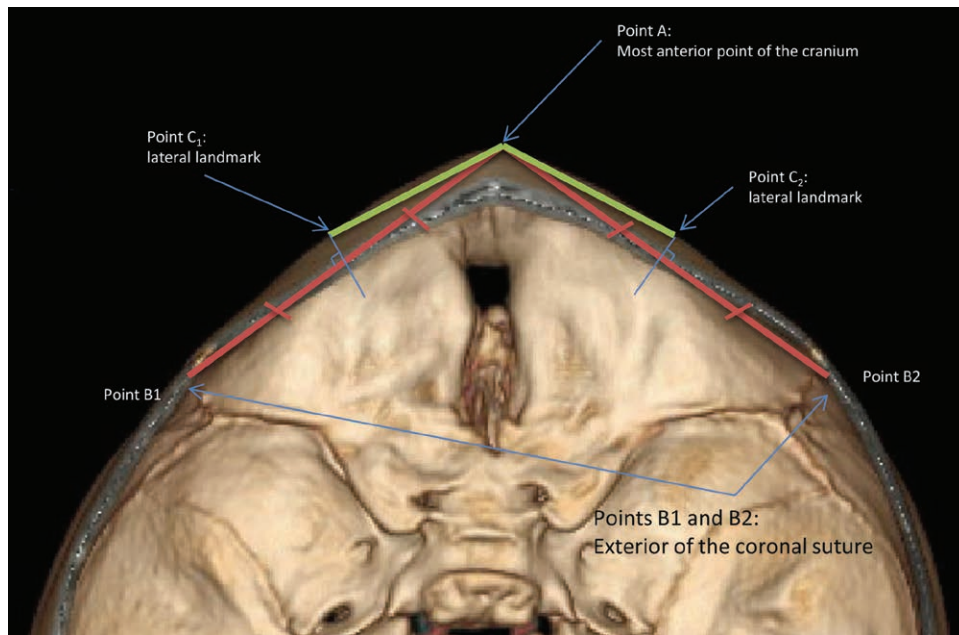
The IFDA is the angle between the line segments connecting points A (most anterior point of the cranium) and C (the lateral landmark bilaterally); or $\angle C_1AC_2$. Steps to define this angle: (1) Using the CT cut normal to the midsagittal plane containing the opisthion and the tips of the clinoid processes, identify point A- the most anterior point of the cranium. (2) Points B1 and B2 are the points most exterior on the coronal sutures. (3) Points C1 and C2 are the most external crossing of the frontal bones where a ray perpendicular to the midpoint of the lines AB_1 and AB_2 .
